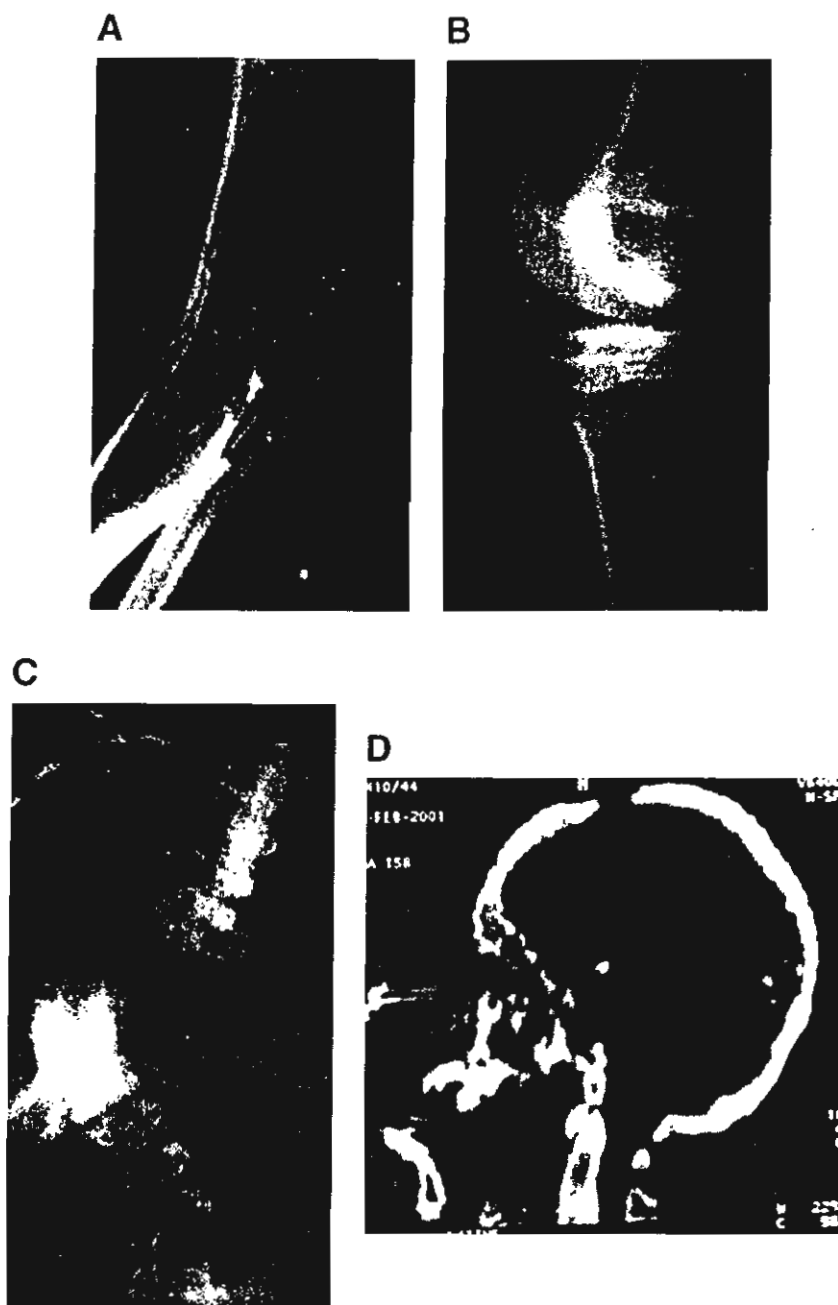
Radiographs. A: Note complete fusion of the humerus, radius, and ulna prohibiting any motion at the right elbow. B: Tibulofibular fusion at the right knee. C: Severe scoliosis and fusion of vertebral bodies of T9 to T12. D: Brain computer tomography with two-dimension multiplanar reconstruction showing microcephaly and severe maxillary hypoplasia.
